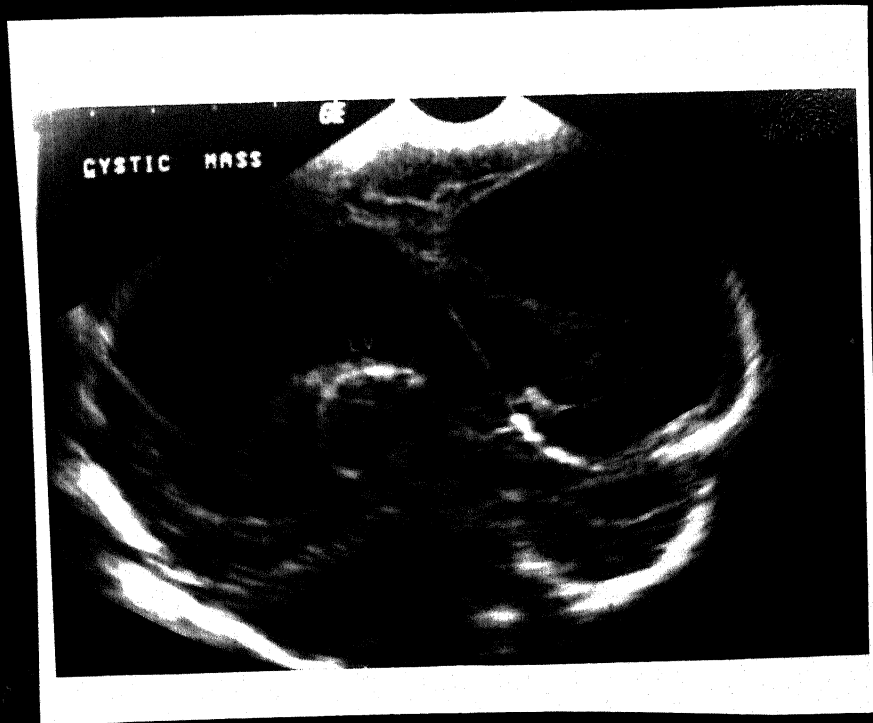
Large cystic area with septae in left Fronto-Parietal region on Coronal Cranial sonogram: Porencephalic Cyst
